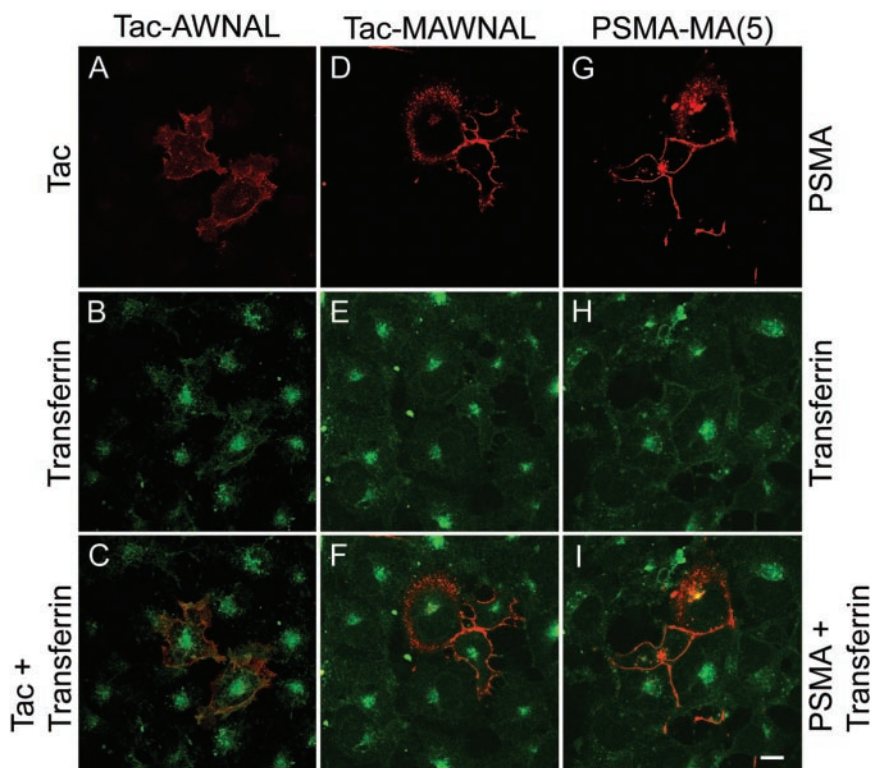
Internalization of Tac-PSMA chimeras Tac-AWNAL and Tac-MAWNAL, and of PSMA-MA(5). (A and D) Internalization of Tac chimera mutants and (G) mAb J591 in transiently transfected COS cells. (B, E, and H) Internalization of FITC-transferrin. (C, F, and I) Merged images. Note the lack of codistribution of Tac-chimera mutants or PSMA-MA(5) and FITC-transferrin. Bar, 5 μ m.
